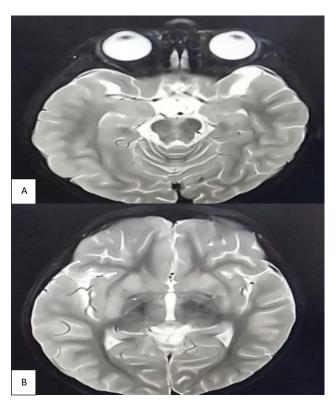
(A and B): MRI brain dated 07/11/2022 multiple bilateral asymmetric patchy ill-defined mildly hyperintense non-enhancing lesions are seen in the basal ganglia, thalami and caudate nuclei and the dorsal pons without any mass effect.
